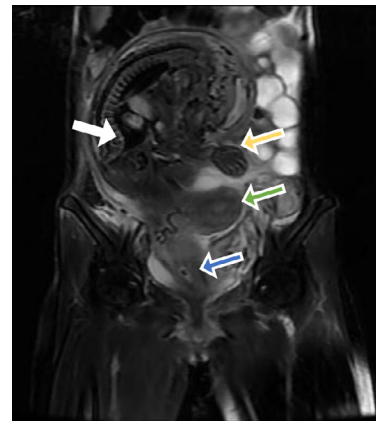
Coronal MRI showed the fetus was in breech position, and uterus was enlarged, especially at the right uterine horn (white arrow). Uterine wall is shown with green arrow. Fetal hand protruded into patient abdominal cavity (yellow arrow), and fetal femur bone protruded into the vagina (blue arrow). (Color version of figure is available online)
